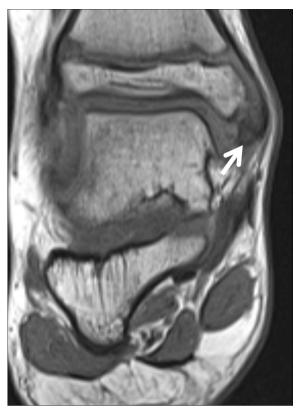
Coronal T1W MR image showing low signal intensity within the tip of the medial malleolus, in keeping with bone marrow edema (arrow).
